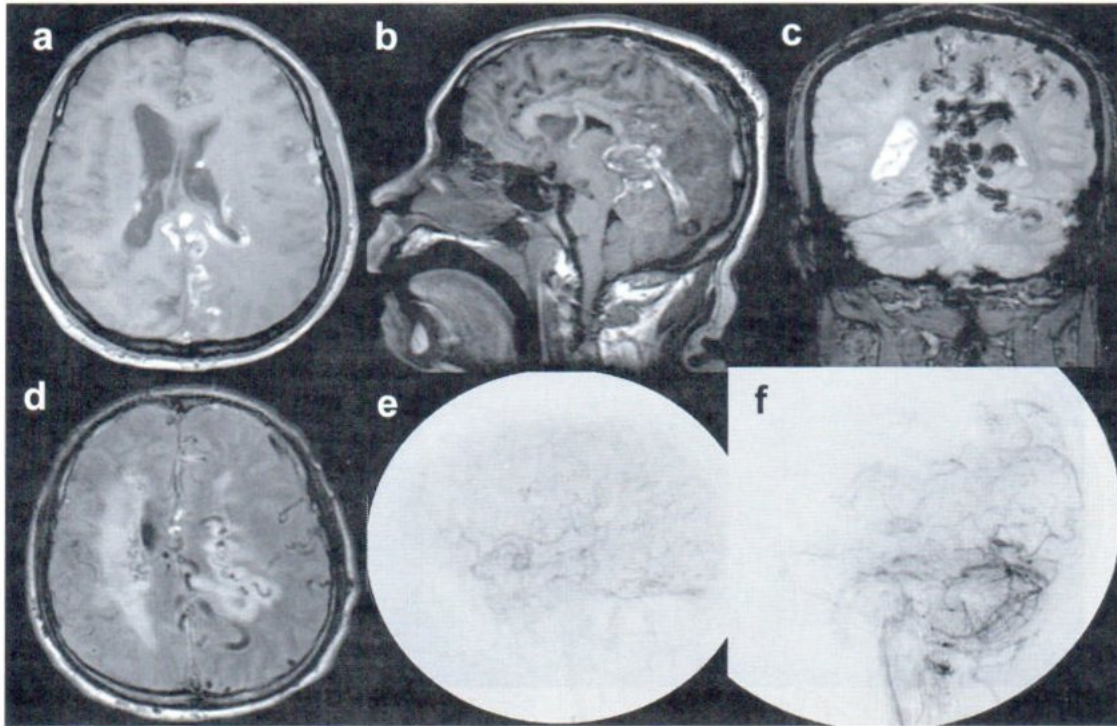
Post embolization MRI noncontrast axial T1WI (a), sagittal T1WI (b), and coronal GRE T2* showed massive thrombosis of the cerebral veins and deep venous system evident by T1 hyperintense signal within the vessel lumens and hypointense signal blooming on GRE T2*. Axial FLAIR (d) showed extensive T2 hyperintense signal at both cerebral hemispheres white matter. Retrospective reviewed of the late venous phase right ICA (e) and vertebral (f) lateral view angiograms showed cerebral venous congestion and no visualization of the deep venous system, confirming evidence of venous thrombosis preembolization.
